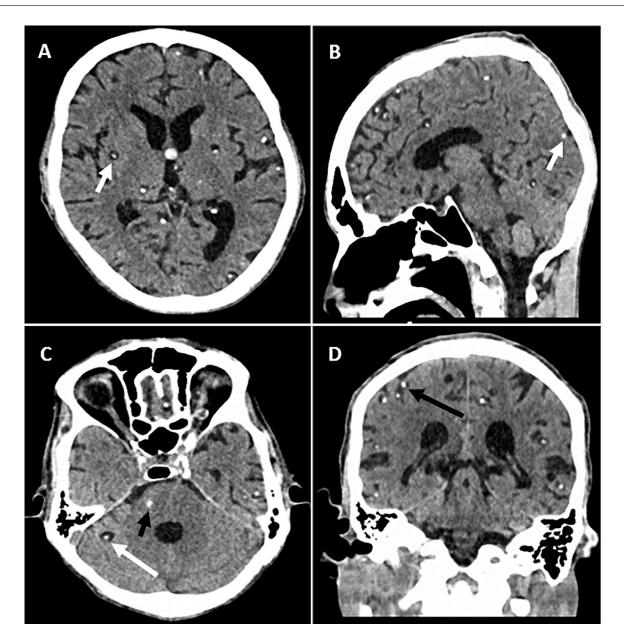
Noncontrast CT images of the brain showing multiple cystic lesions with central calcification in grey and white matter of bilateral cerebral hemispheres (short white arrows), right cerebellar hemisphere (long white arrow), pons (short black arrow) and subarachnoid spaces (long black arrow).
